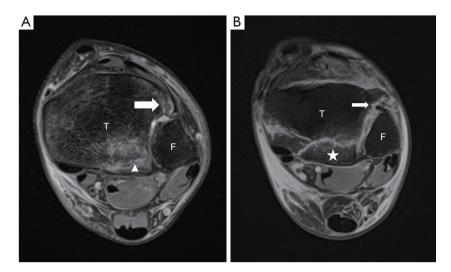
Left ankle proton density axial MRI of case 1 (A) and case 2 (B) obtained at 1 week. (A) Proton density axial MRI showing tibia (T), tibial bony avulsions of the AITFL (Chaput fragment: large white arrow) and PITFL (Volkmann fragment: white triangle). The fibula (F) is anatomically placed in the tibial notch. (B) Proton density axial MRI showing tibia (T), tibial bony avulsions of PITFL (Volkmann fragment: white star) and rupture of the AITFL (small white arrow). The fibula (F) is anatomically placed in the tibial notch. MRI, magnetic resonance imaging; AITFL, anterior inferior tibiofibular ligaments; PITFL, posterior inferior tibiofibular ligament.
